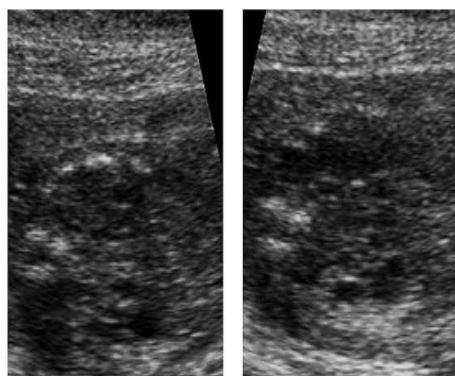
Bilateral dysplastic kidneys seen on the antenatal ultrasound.
